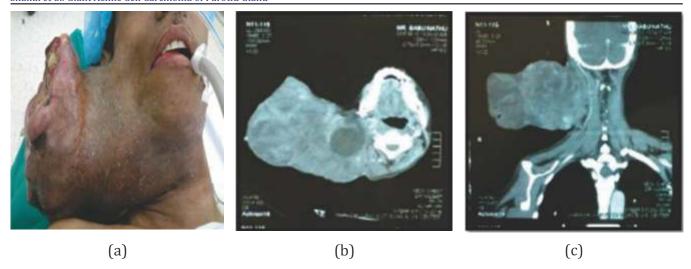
(a) Clinical picture of the patient on OR table (b) Axial and (c) Coronal images of the CT scan
